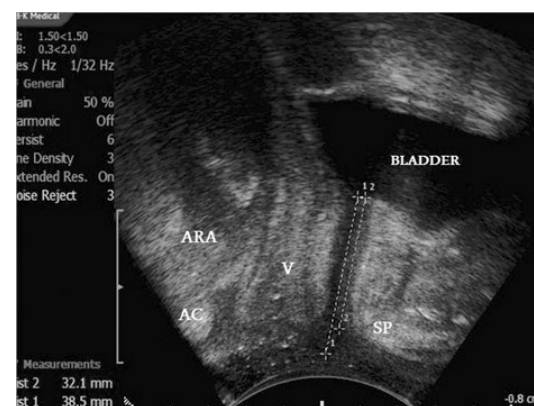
Transperineal ultrasound of pelvic floor. AC- anal canal, SP- pubic symphysis, V - vagina, ARA - anorectal angle. The measurements of urethral length is 38.5 mm and BSD is 32.1 mm in this 30 Y incontinent patient.
